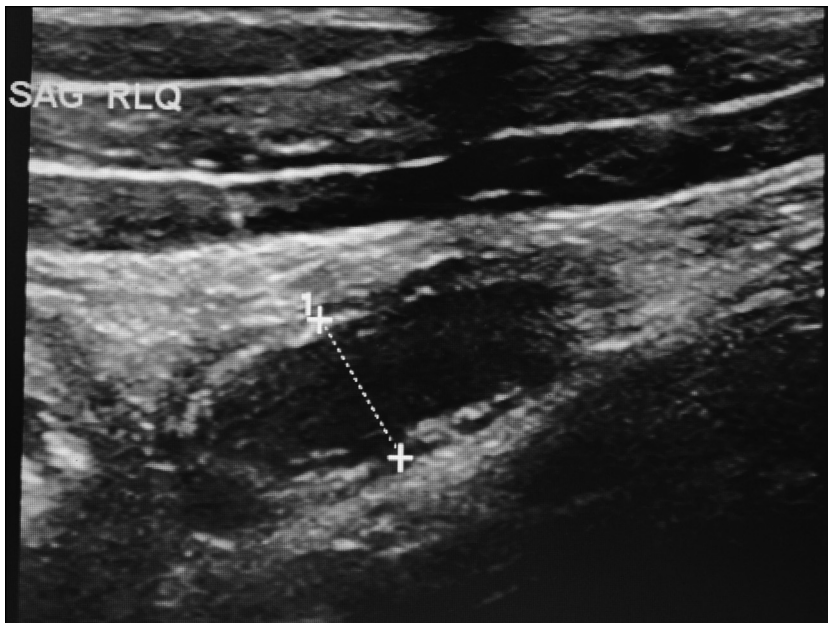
A 15-year-old girl who has had right lower quadrant pain, emesis, and fever. The appendix is unable to be compressed and measures 8 mm in diameter, which is an ultrasonographic sign positive for appendicitis. Courtesy of The Children's Hospital of Alabama, Birmingham, Ala.
